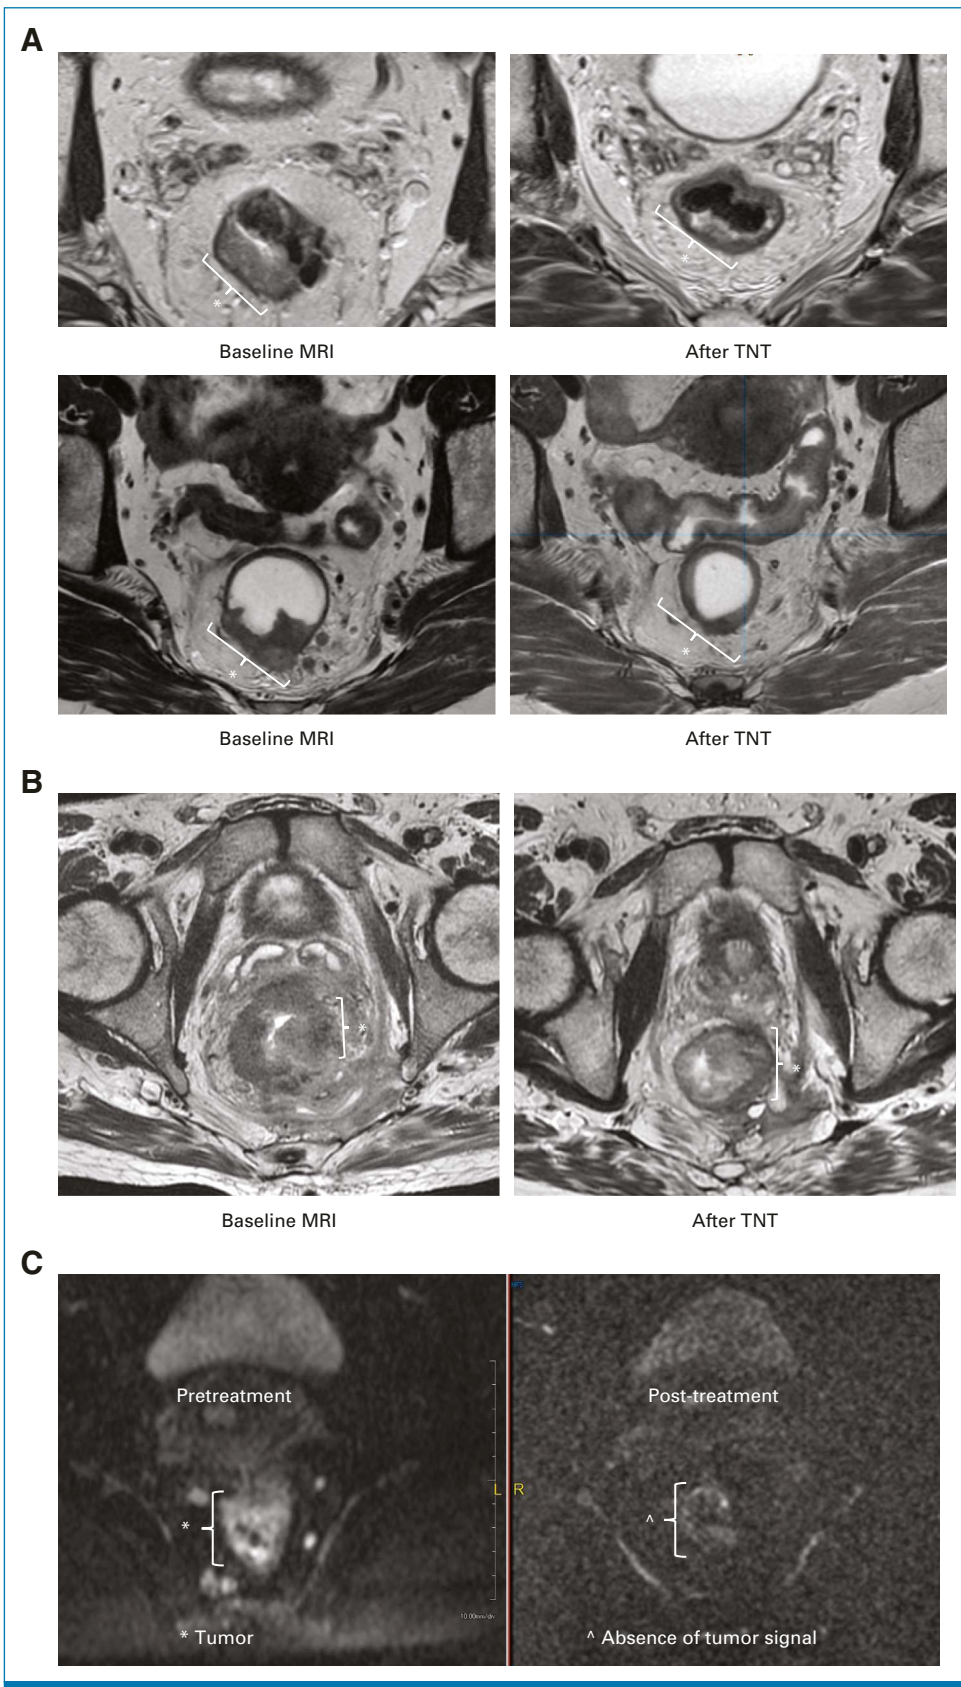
(A) MR-TRG grade 1 example, no tumor evidence after TNT. (B) MR-TRG grade 3 example, residual tumor after TNT. (C) Absence of tumor signal on DWI. DWI, diffusion-weighted imaging; MR-TRG, magnetic resonance tumor regression grade; TNT, total neoadjuvant therapy.
